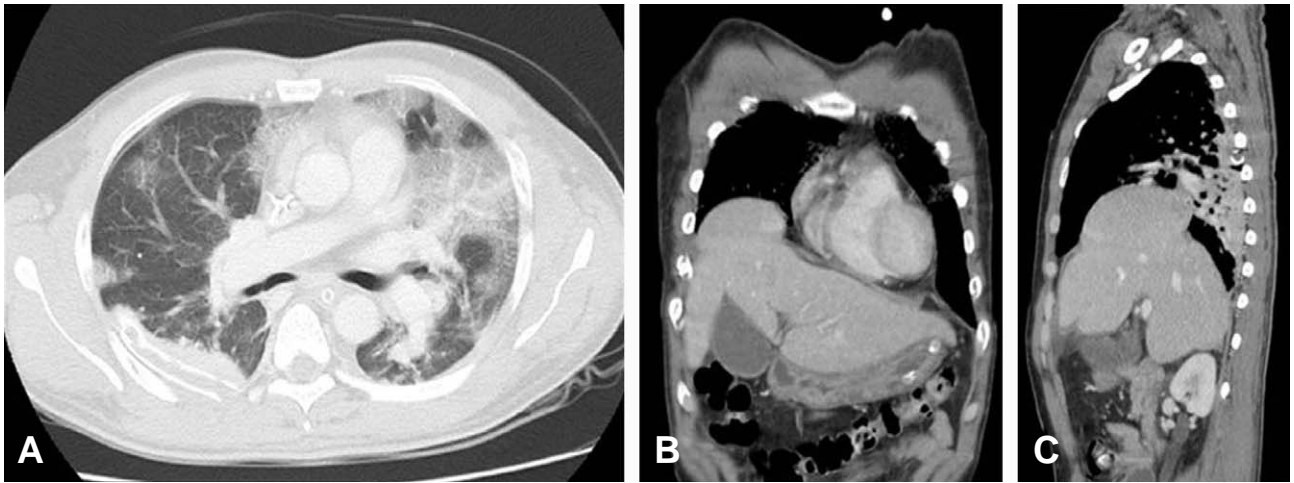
Chest CT showing aggravation of bilateral pneumonia (A), on coronal (B) and sagittal (C) views, the chest CT shows rupture of the right hemi-diaphragm.
